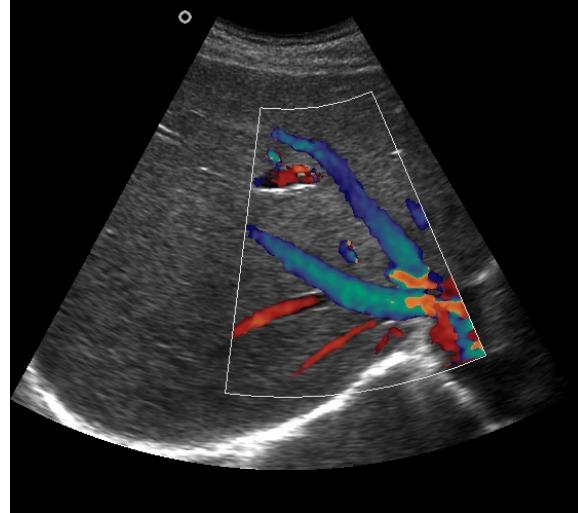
Doppler representation of blood flow in the liver.
